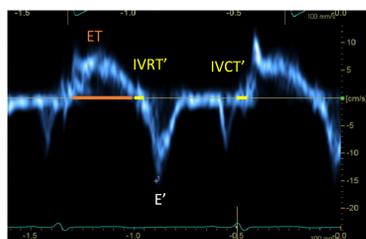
In the apical four chamber view, tissue Doppler of the mitral inflow at the septal and lateral mitral valve tips were used to acquire Septal e' and Lateral e' annular velocities respectively. IVCT' was calculated as time from the end of late diastolic filling to the beginning of systolic ejection. ET was measured as time of LV outflow and IVRT' was measured as time between the end of systolic ejection to the beginning of early diastolic filling. Myocardial performance index (MPI), a measure of overall cardiac function, was calculated as (IVCT'+IVRT')/ET.
